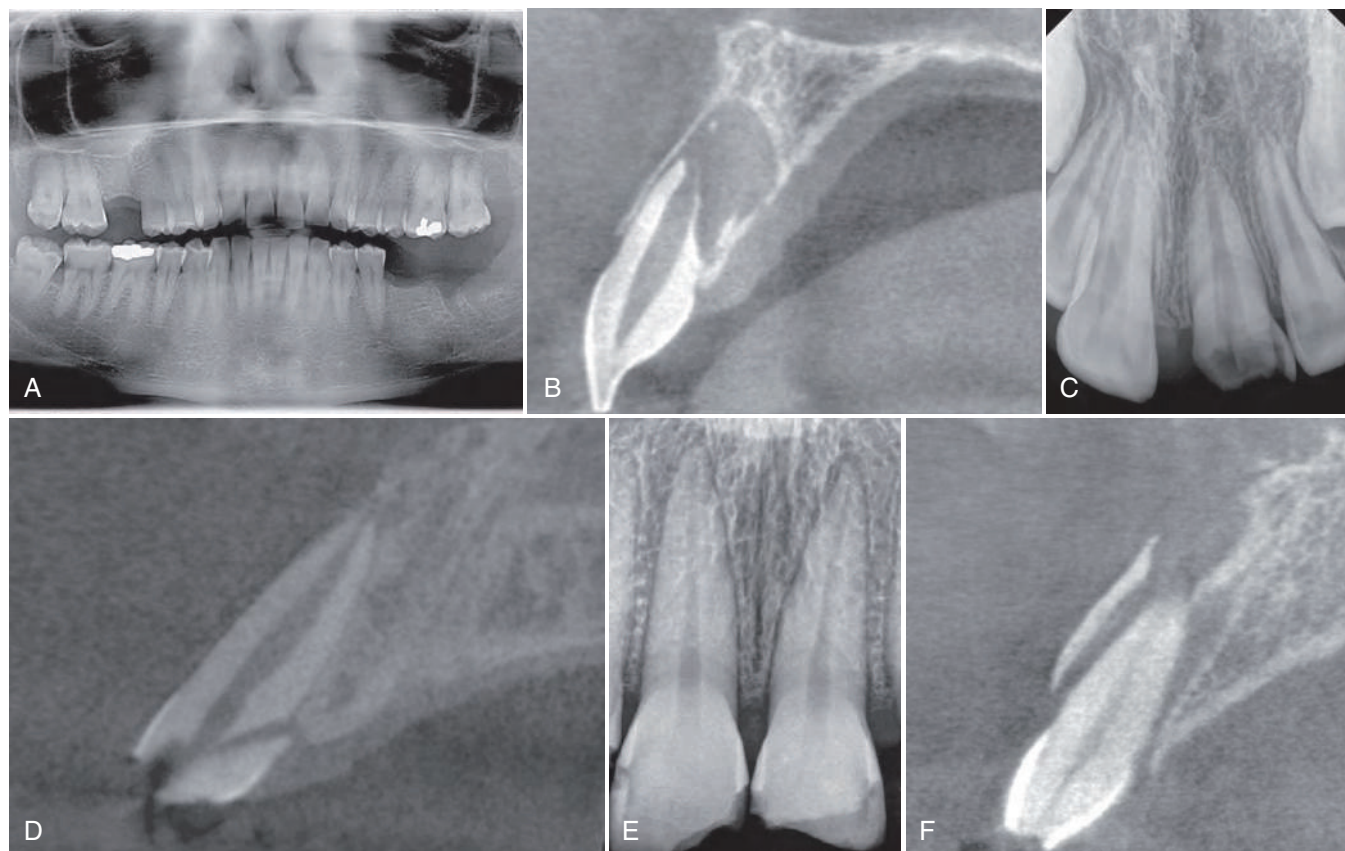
A, Panoramic radiograph taken on a patient with past history of dentoalveolar trauma. Tooth #9 appeared to have arrested root development with a periapical radiolucency. B, Sagittal view of tooth #9 of same patient from CBCT imaging. This revealed that tooth #9 had arrested root development, a large PA radiolucency, and extensive root resorption along the palatal surface that was *not* evident on the panoramic image. C, Periapical radiograph of tooth #9 with extensive complicated crown fracture. The clinical examination revealed the crown fracture extended subgingivally on the palatal aspect. D, Sagittal view of tooth #9 of same patient from CBCT imaging. This revealed that the apical extent of the fractured palatal portion extended just apical to the crest of bone. The correct diagnosis of this injury was complicated crown-root fracture. E, Periapical radiograph of teeth #8, #9 revealed crown fractures. F, Sagittal view of tooth #9 of same patient from CBCT imaging. This revealed that tooth #9 suffered a lateral luxation displacement injury with extensive concomitant alveolar fracture. The necessary treatment of repositioning and splinting was apparent.
